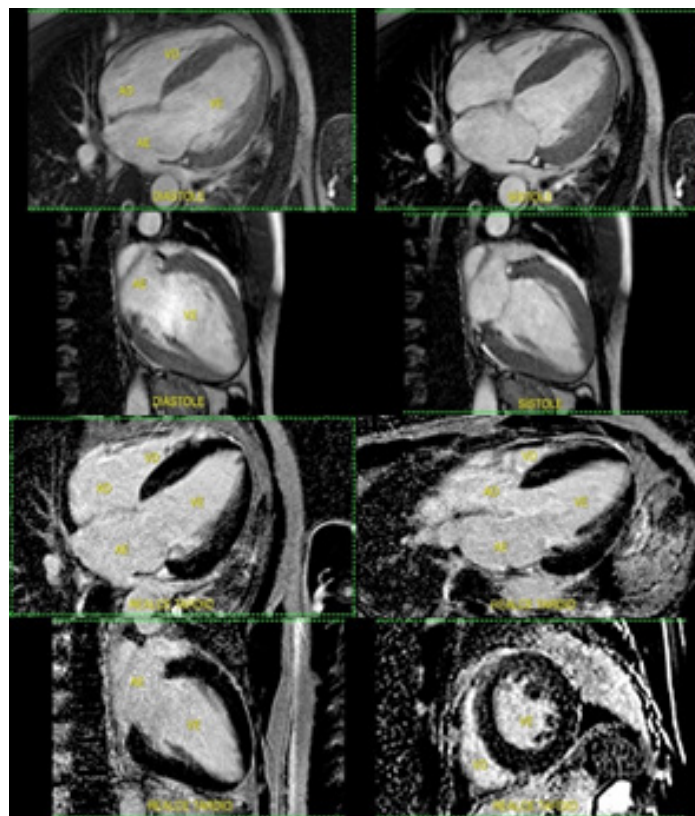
Dynamic contrast-enhanced MRI (top) and delayed enhancement (bottom).
